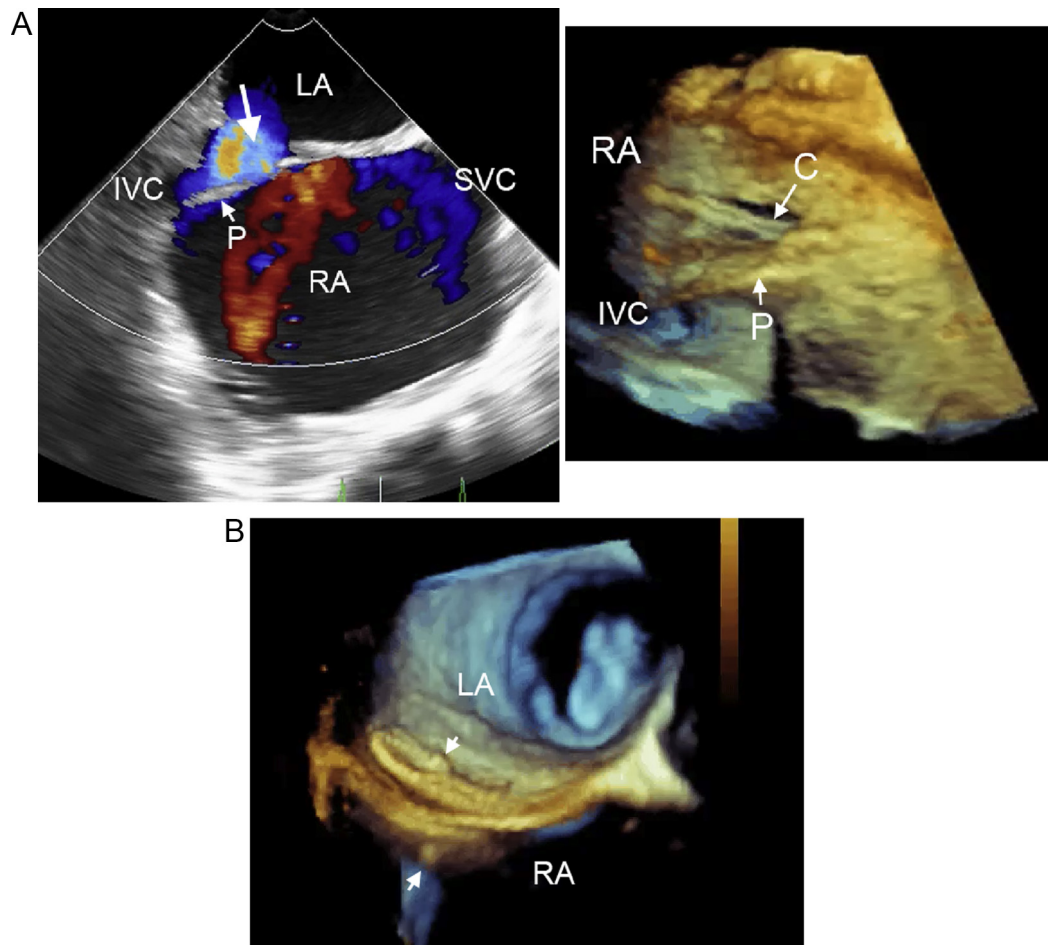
(A) 2D TEE showed a postoperative residual atrial septal defect (arrow) near the IVC, with an independently dehiscent path mass (P) (left frame). 3D TEE enface RA view revealed the presence of the sheath catheter (C) passed through an ovoid defect with redundant path tissue (P) located in the inferior-posterior part of the atrial septum with a 3–4 mm rim of tissue between the defect and the IVC (right frame). (B) 3D TEE showing an 18-mm cribriform device (arrows) successfully deployed in its proper position without any residual leak. 2D = two dimensional; 3D = three dimensional; IVC = inferior vena cava; LA = left atrium; RA = right atrium; SVC = superior vena cava; TEE = transesophageal echocardiography.
